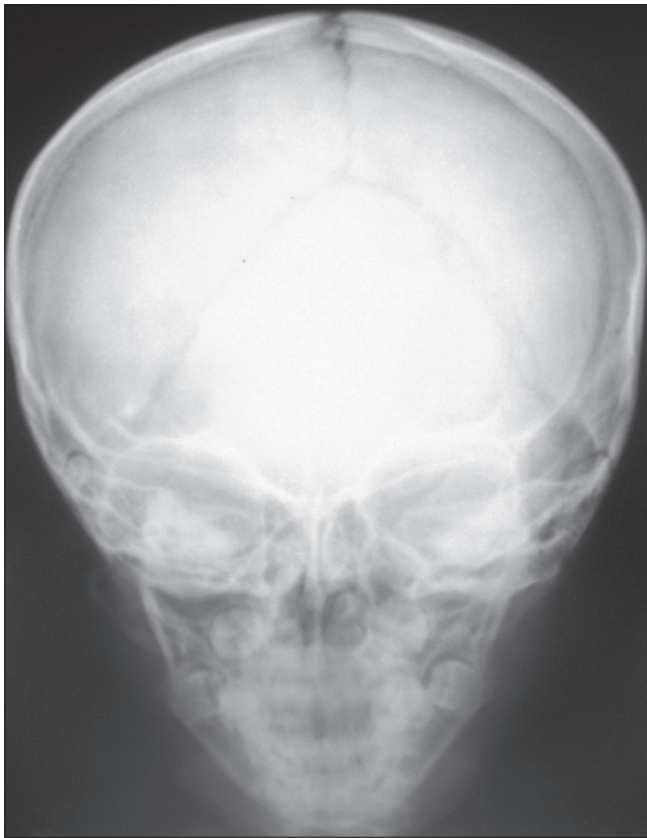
X-ray of the skull showing diastasis of the sutures and prognathism.
